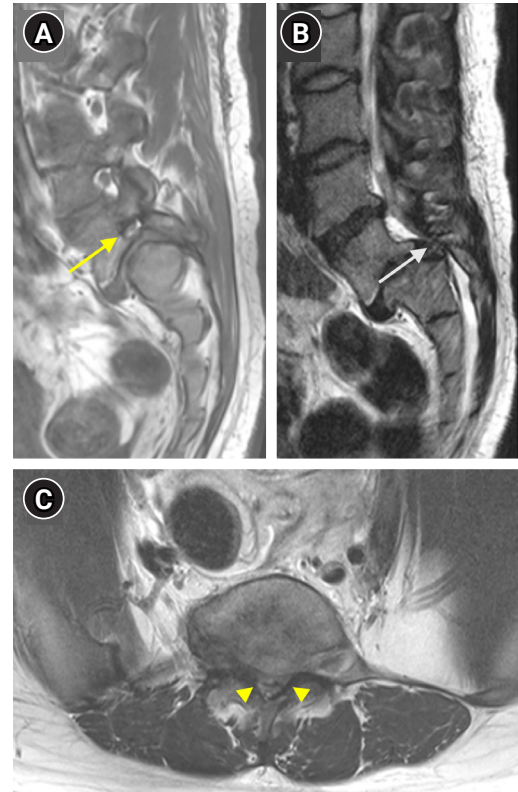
Lumbar spine magnetic resonance imaging demonstrating severe central canal stenosis and foraminal stenosis associated with dysplastic spondylolisthesis at the L5–S1 level. (A) Sagittal T1-weighted magnetic resonance image demonstrating high-grade L5–S1 dysplastic spondylolisthesis with severe foraminal stenosis (yellow arrow). (B) Sagittal T2-weighted magnetic resonance image showing severe central canal stenosis at the L5–S1 level (white arrow). (C) Axial T2-weighted magnetic resonance image demonstrating severe central canal stenosis (yellow arrowheads).
